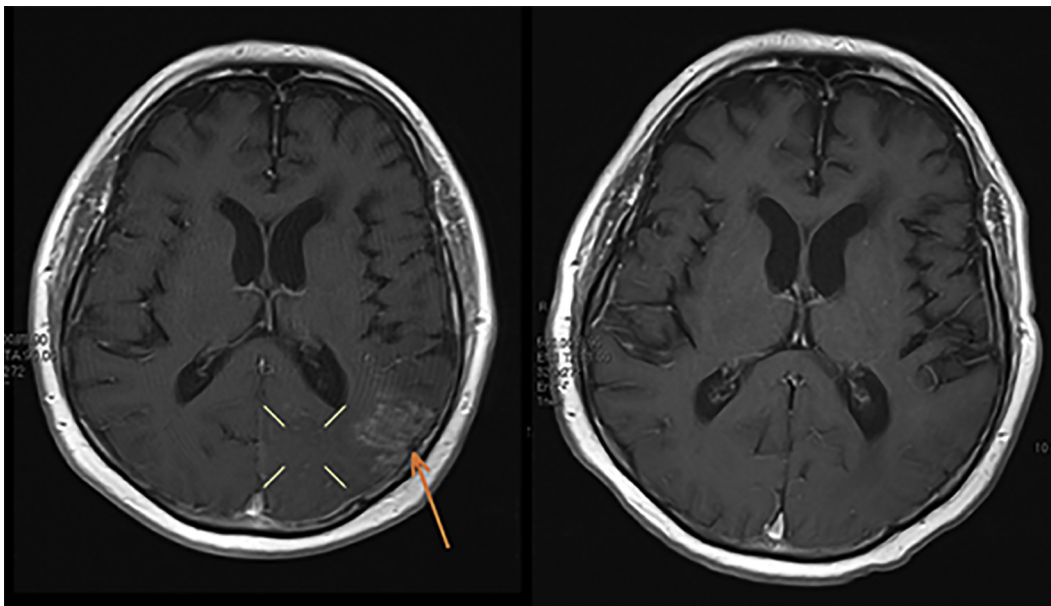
T1-weighted images postgadolinium administration. At the time of presentation (left), cortical enhancement can be seen peripheral to the known temporoparietal tumor (arrow), which also extends into the left occipital lobe. Subtle occipital gadolinium enhancement can also be seen (marker). Both these findings have resolved on follow-up imaging 3 weeks later (right).
